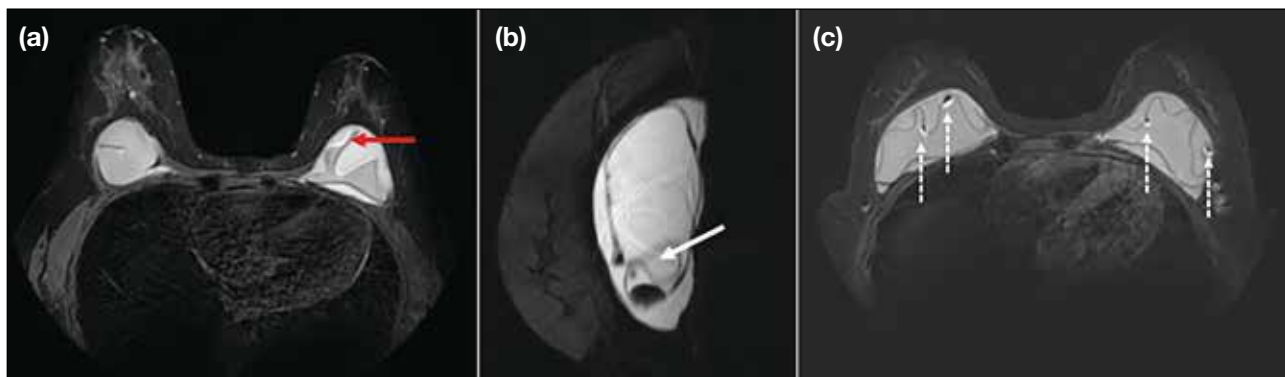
(a) Short-tau inversion recovery (STIR) axial magnetic resonance imaging (MRI) reveals a left breast single-lumen implant intracapsular rupture with wavy lines within the capsule (red arrow) [the ‘linguine sign’]. (b) T2-weighted STIR silicone-only sagittal MRI showing focal invagination of the breast single-lumen implant shell against the fibrous capsule (white arrow) [the ‘keyhole sign’]. (c) STIR axial MRI showing multiple T2-weighted hyperintense foci within the single-lumen implant (dashed arrows) [the ‘droplets sign’].
